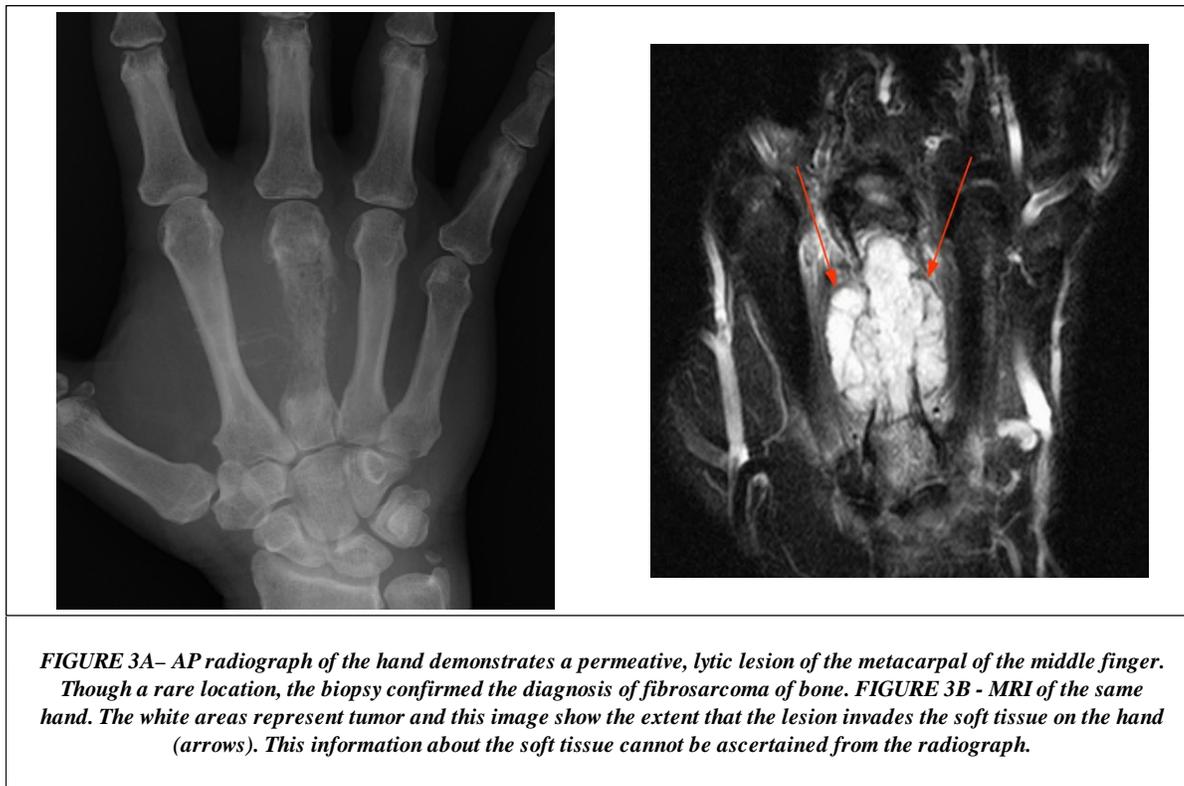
AP radiograph of the hand demonstrates a permeative, lytic lesion of the metacarpal of the middle finger. Though a rare location, the biopsy confirmed the diagnosis of fibrosarcoma of bone. FIGURE 3B - MRI of the same hand. The white areas represent tumor and this image show the extent that the lesion invades the soft tissue on the hand (arrows). This information about the soft tissue cannot be ascertained from the radiograph.
